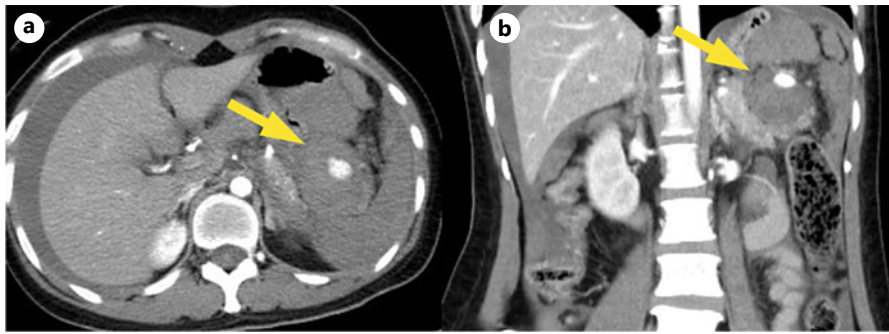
a, b Contrast-enhanced abdominal CT scan revealed significant fluid accumulation around the stomach, liver, spleen, and pelvis, indicating a ruptured splenic artery aneurysm (yellow arrow).
